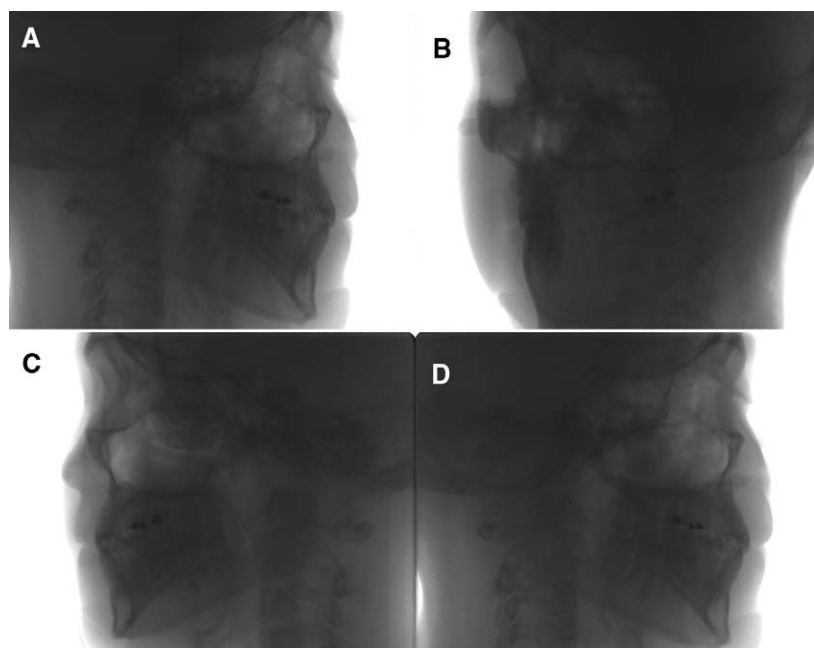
Four basis-image frames from 306 that comprise primary data for iCAT CBCT for 20-second full scan: A, frame 1, first basis image; B, frame 75; C, frame 152; D, frame 306, final basis image. Each image is approximately equivalent to individual cephalogram.
